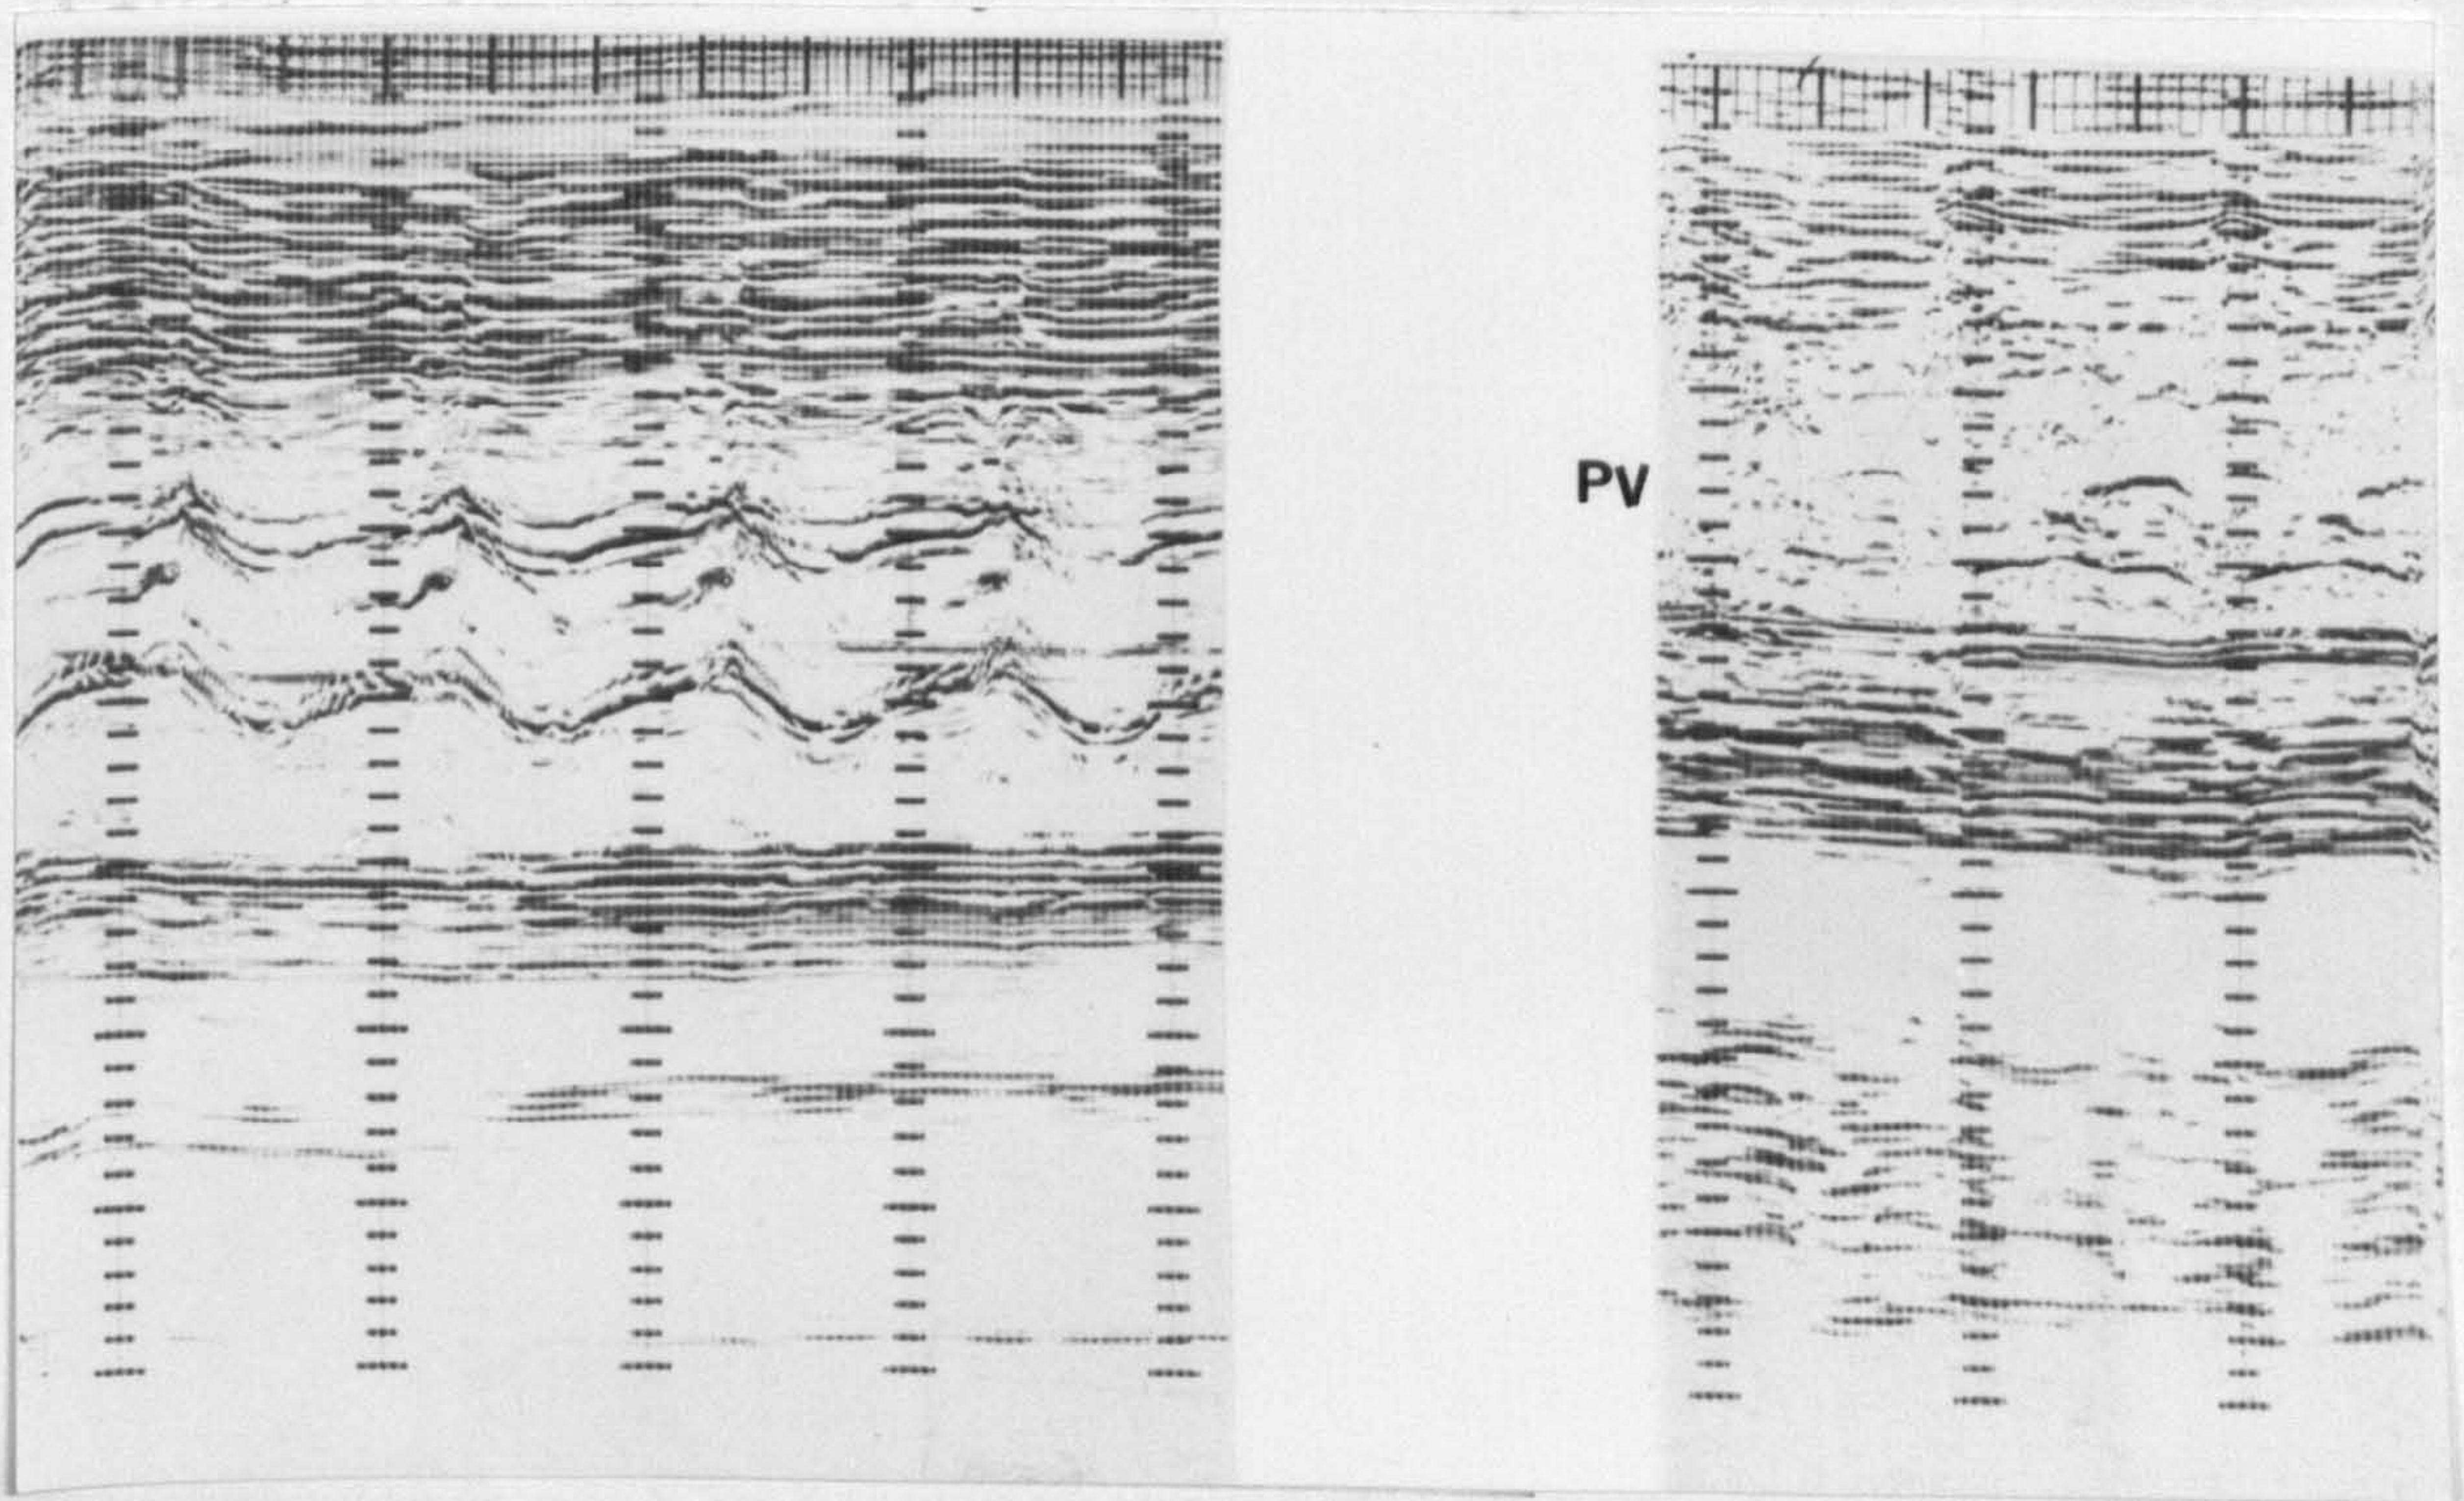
M mode echocardiogram in Case 2.
